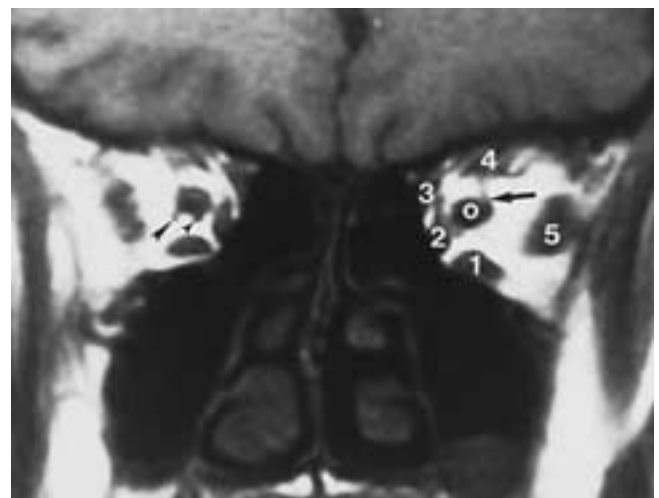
Normal MR imaging anatomy. T1-weighted MR coronal image shows the inferior rectus muscle (1); medial rectus muscle (2); superior oblique muscle (3); superior rectus muscle (4); lateral rectus muscle (5); optic nerve (o); long posterior ciliary arteries (*arrowheads*); and presumed ciliary ganglion (*arrow*).
